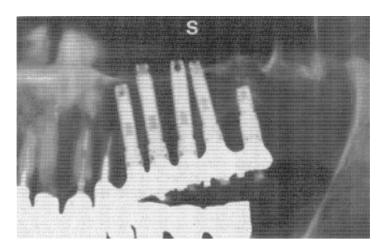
(b). Radiograph of the same area six months after insertion of implants of S53P4 bioactive glass shows considerable increase in the amount of bone on the floor of the maxillary sinus. Note good osseointegration of the fixtures. (Courtesy of Dr. Juha Peltola, Department of Oral Diseases, University Central Hospital of l'urku, Turku, Finland.)
